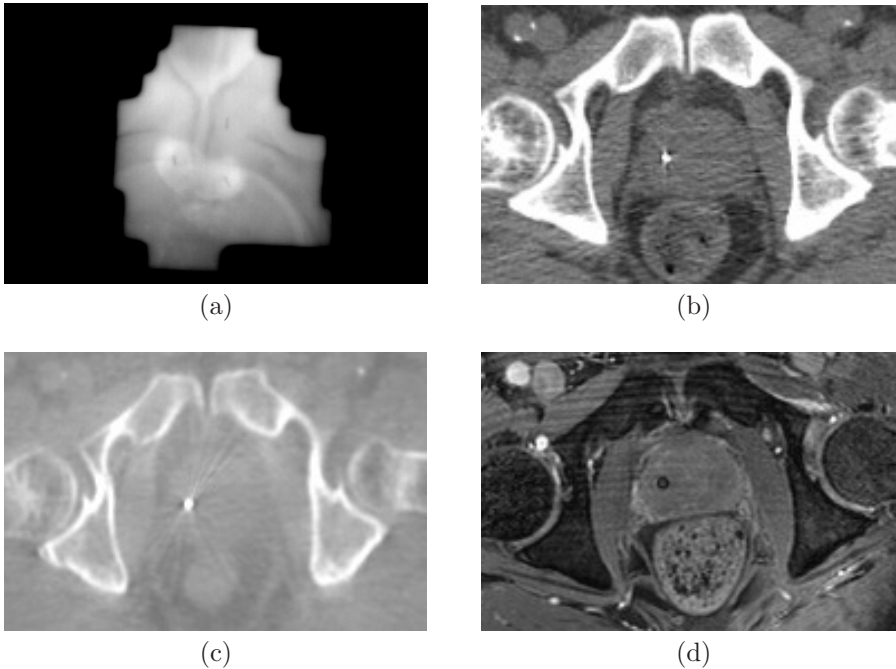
Four potential in-room imaging modalities for image guided prostate radiotherapy; (a) portal image showing pelvic bones and the implanted markers in the prostate, (b) pre-treatment CT, (c) CBCT acquired just prior to fraction delivery, (d) pre-treatment MRI as used in our department as a delineation guide. (a) courtesy of Alexis Kotte; (b)–(d) courtesy of Ellen Kerkhof.
